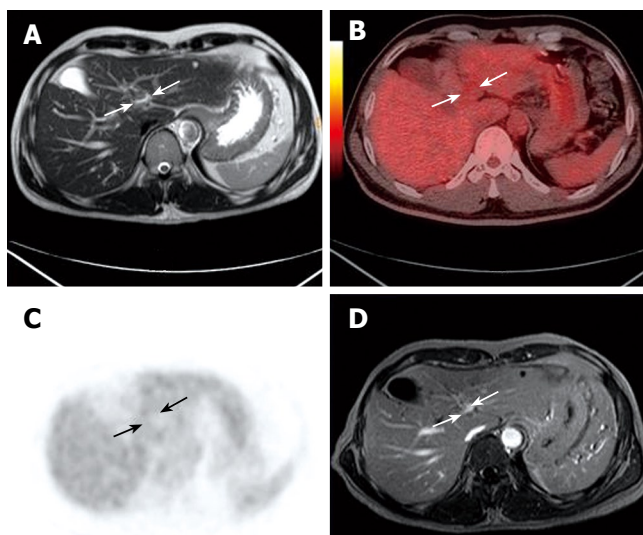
MRI showing a portal vein thrombus in a 44-year-old man six months after HCC resection (white arrows, A). PET/CT fused images (white arrows, B) and PET (black arrows, C) reveal no highly metabolic thrombus in the left branch. LP was recanalized in the contrast MRI at 10 mo follow-up (white arrows, D).
